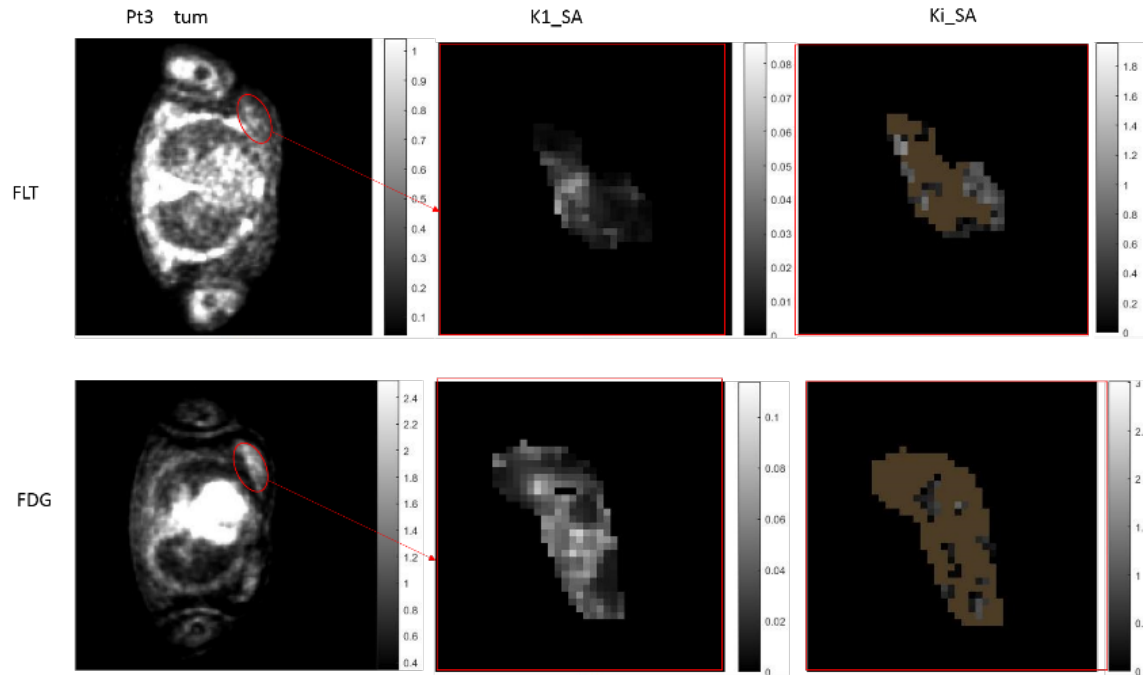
DCIS patient n.3. In the first row, analysis results of the dynamic FLT PET data. From left: phase n. of the PET dynamic scan, SA K_1 , SA on a zoomed section of the breast. In the second row, results from the quantification of dynamic FDG PET data.
